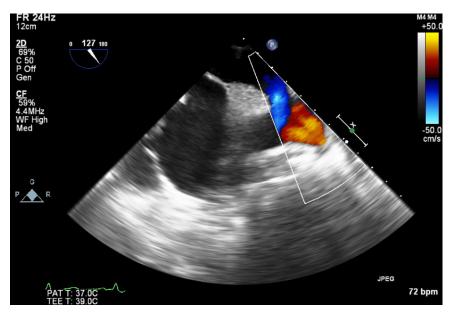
Midesophageal bicaval color Doppler transesophageal echocardiography image showing 2 separate jets of pulmonary venous blood flow (red) entering the distal superior vena cava.
